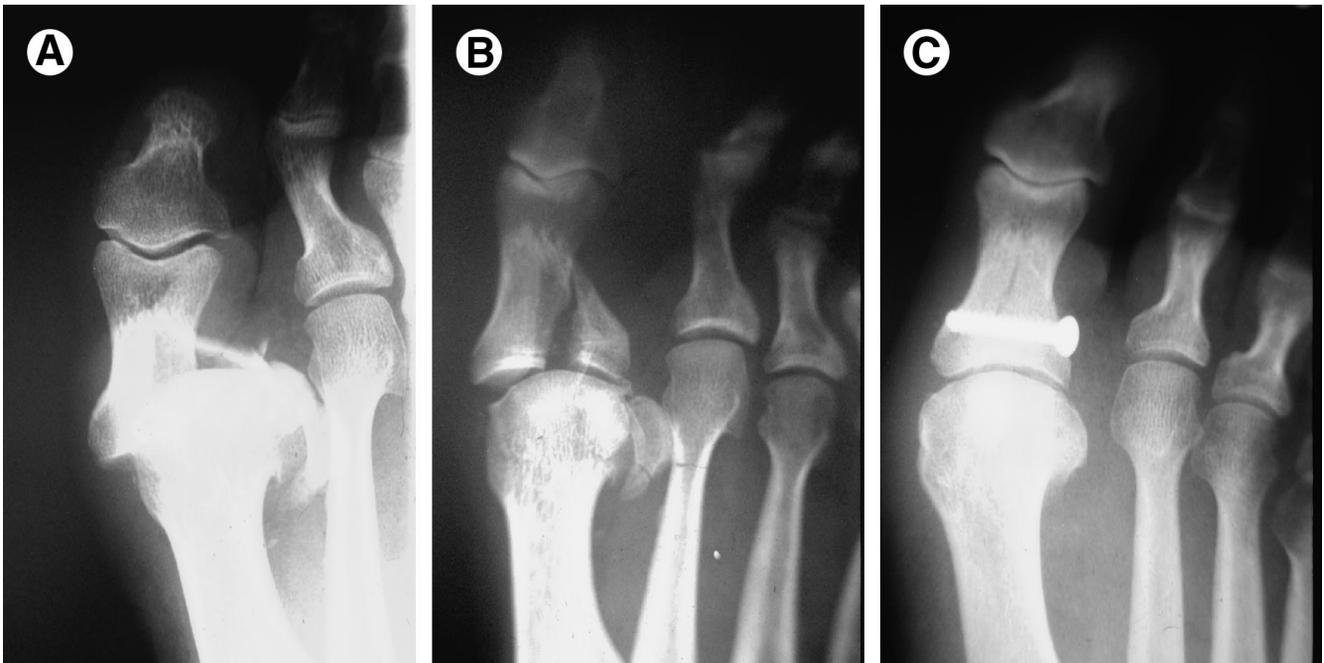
Fracture dislocation of the first MTP joint is shown in (A) anteroposterior and (B) oblique views. (C) Anteroposterior radiograph of surgical reduction with screw fixation.
